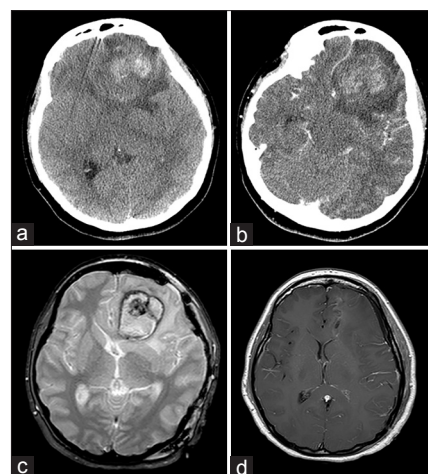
Left frontal hemorrhage from Case 3. (a) Computed tomography of the head showed a large left frontal intracerebral hemorrhage with subfalcine shift and perilesional edema. (b) Computed tomography with contrast showed partial enhancement of the lesion without any vascular feeders. (c) Magnetic resonance imaging brain, gradient echo sequence, showed a central lesion with surrounding hemorrhage, suggestive of cavernous malformation. (d) Postoperative magnetic resonance imaging brain with contrast showed complete resection of the lesion and hematoma, with resolution of mass effect
